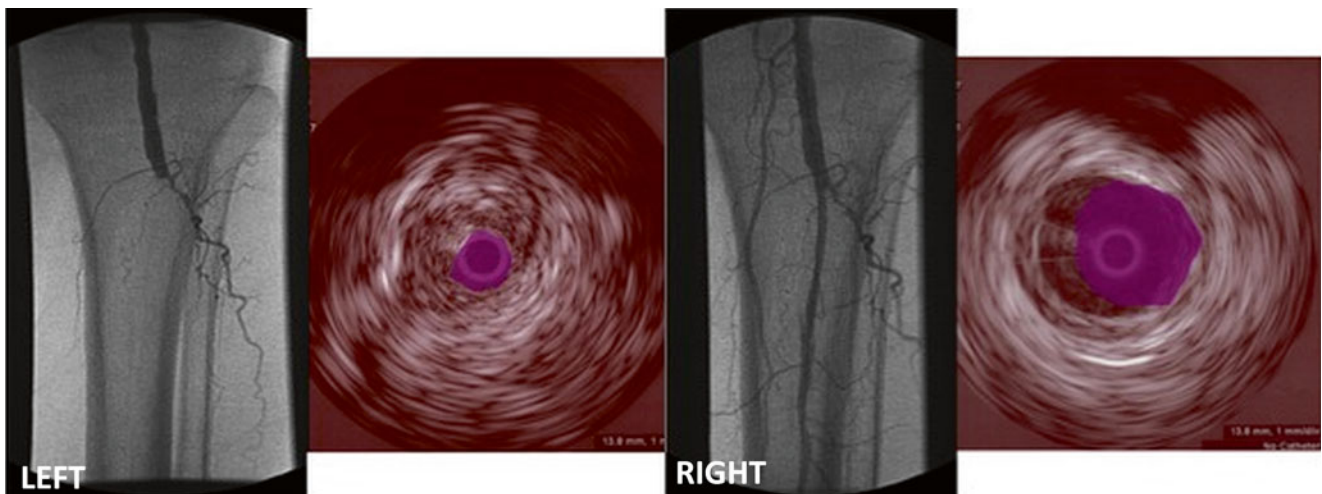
Left:* Initial angiogram showing totally occluded distal popliteal artery with no distal filling by angiography. CTA and MRA also showed no distal targets. *Right:* Lesion could not be crossed with a guide wire. Step by step technique was utilized to cross revealing a widely patent channel after laser alone (Subsequent PTA was performed with a 3mm balloon not shown here)
